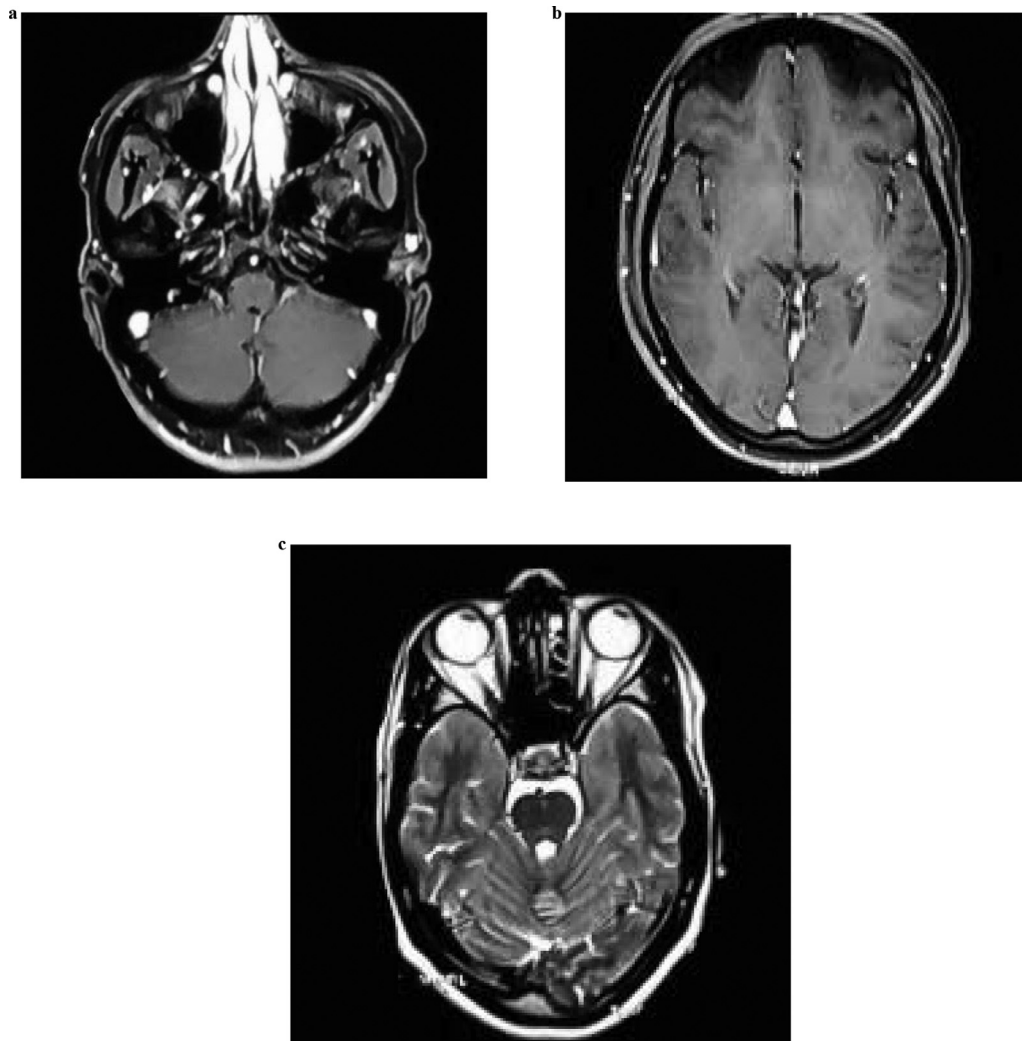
(A-C) Brain magnetic resonance imaging (T2-weighted image) showing no specific pathology.
